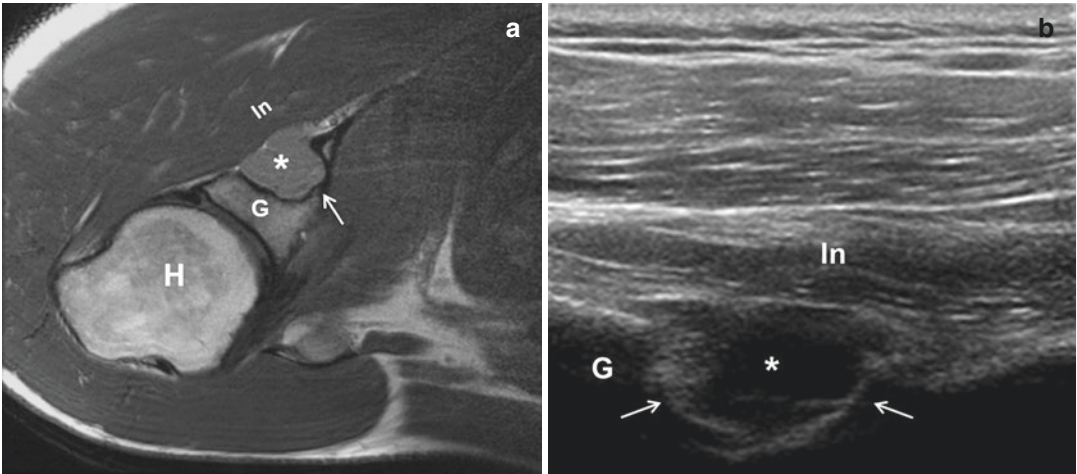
Axial T1-weighted MR image (a) and corresponding ultrasound image (b) demonstrate a paralabral cyst (asterisk) within the spinoglenoid notch (arrows).
